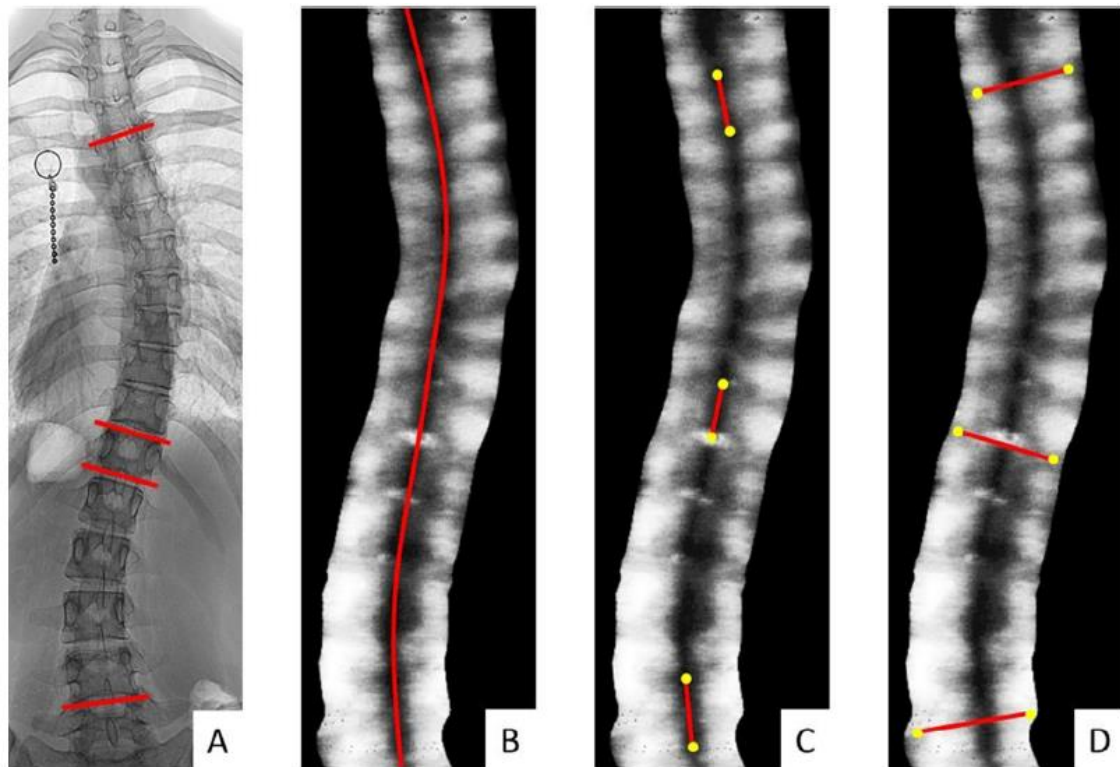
All images show spinal angles of the same patient. Image A shows the coronal Cobb angle measured on a radiograph. B shows automatic obtained SP angle by Scolioscan software. Both C and D show manually obtained spinal angles by SP and TP respectively. The angle between the red lines of the most tilted vertebrae were measured [35].
